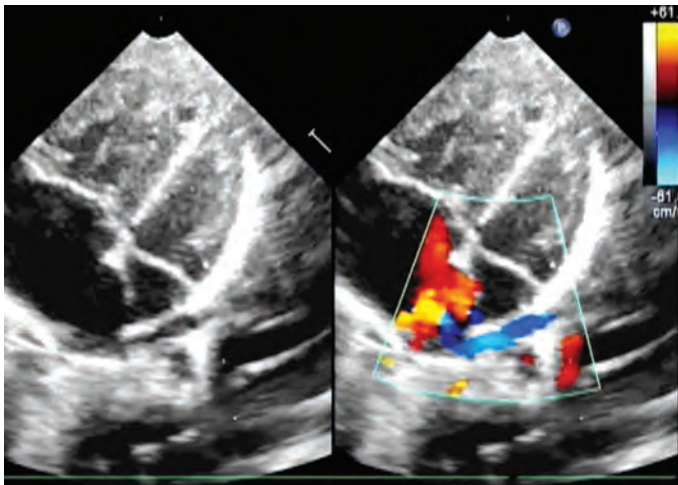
Cardiac TAPVC: Apical four-chamber view showing a small LA, dilated RA, and common chamber draining into RA.
